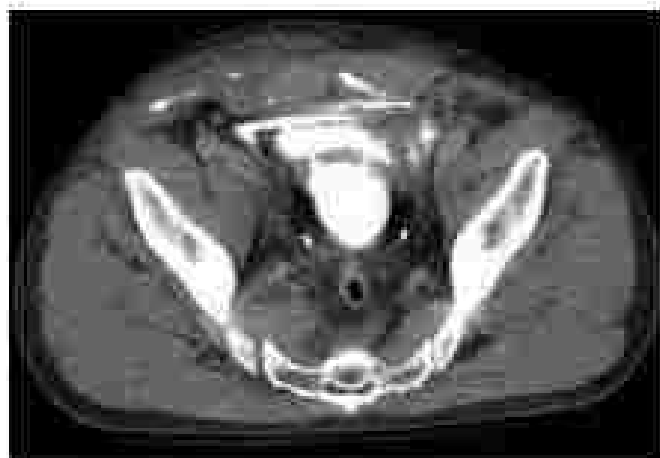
Computed tomography cystogram demonstrating extraperitoneal bladder rupture with contrast extravasation into the retroperitoneum.
